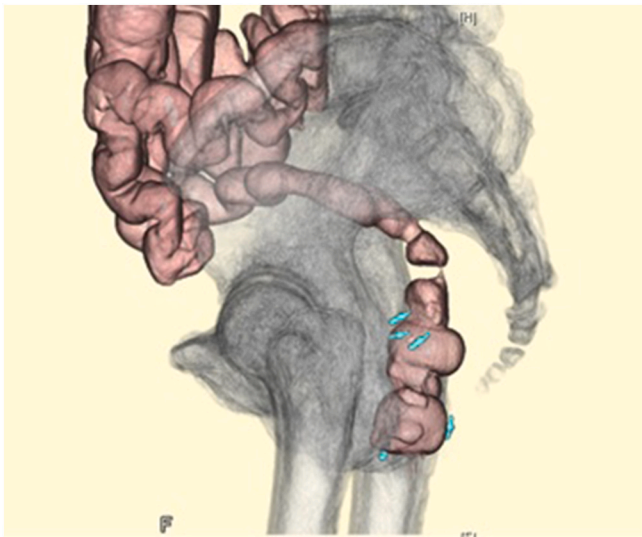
A clip was placed at the tip of the prolapsed rectum and the level of the anal verge, and computed tomography colonography was performed after the rectum was returned. Stratified bending of the rectum was observed. Straining stratified bending was necessitated.
